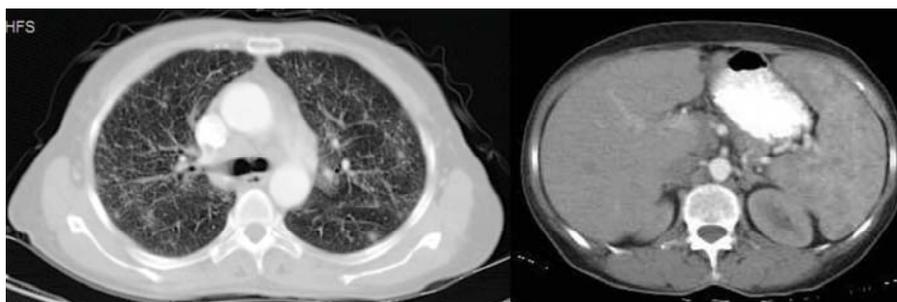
Thoraco-abdominal CT. Bilateral reticulonodular infiltration and mosaic pattern of lung attenuation. Hypodens areas within the spleen
